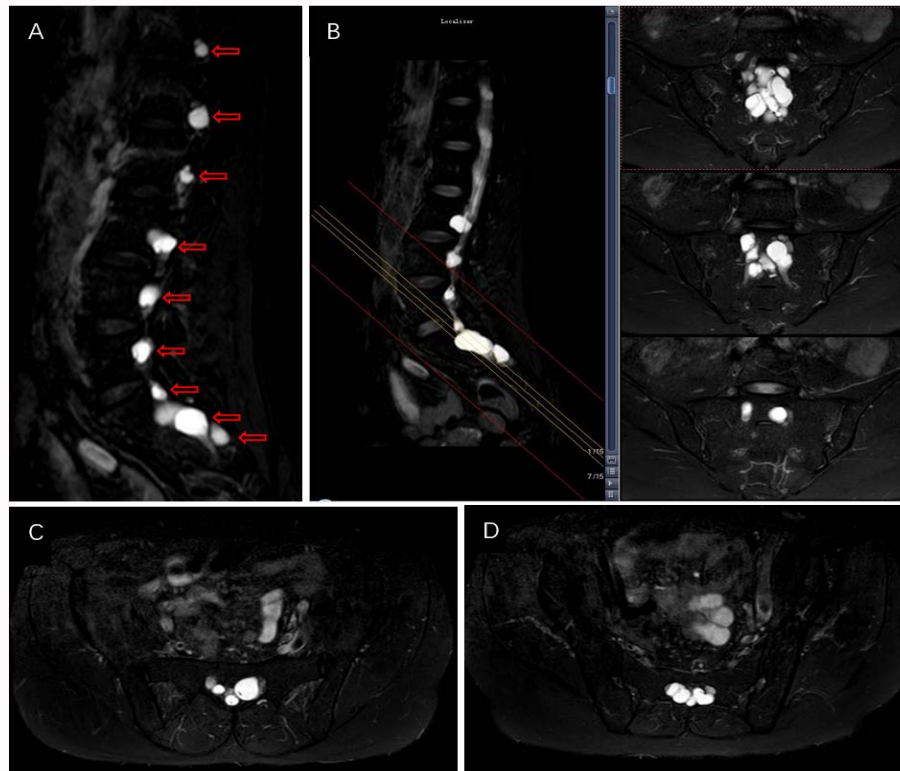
A, B) There are numerous beaded cysts along the spinal canal on MRI sagittal view. C, D) On the coronal plane, part of the spinal canal was dilated and bulked out of the bilateral foramina, in which the cauda equina nerve was visible.
